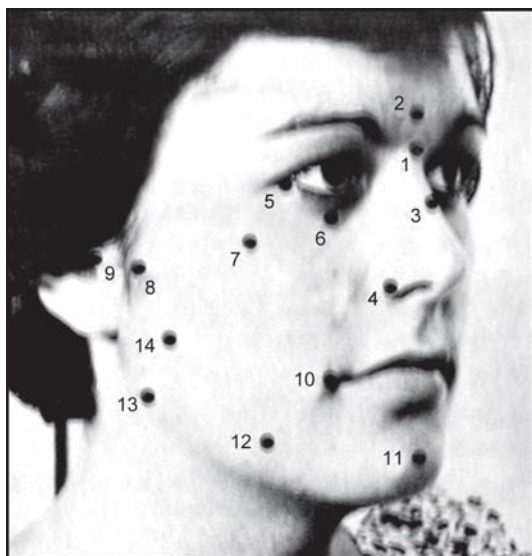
Skin surface land marks useful in intraoral radiography—
